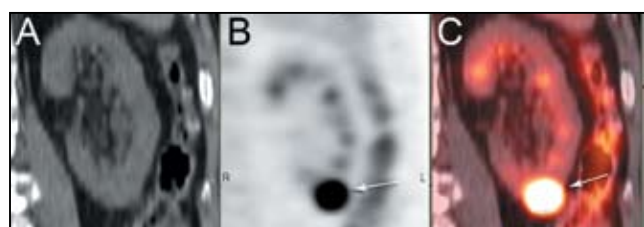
Axial CT (A), PET (B), and fused PET/CT (C) images show focal intense uptake in the lower pole of the left kidney (white arrows) without an unenhanced CT correlate.
